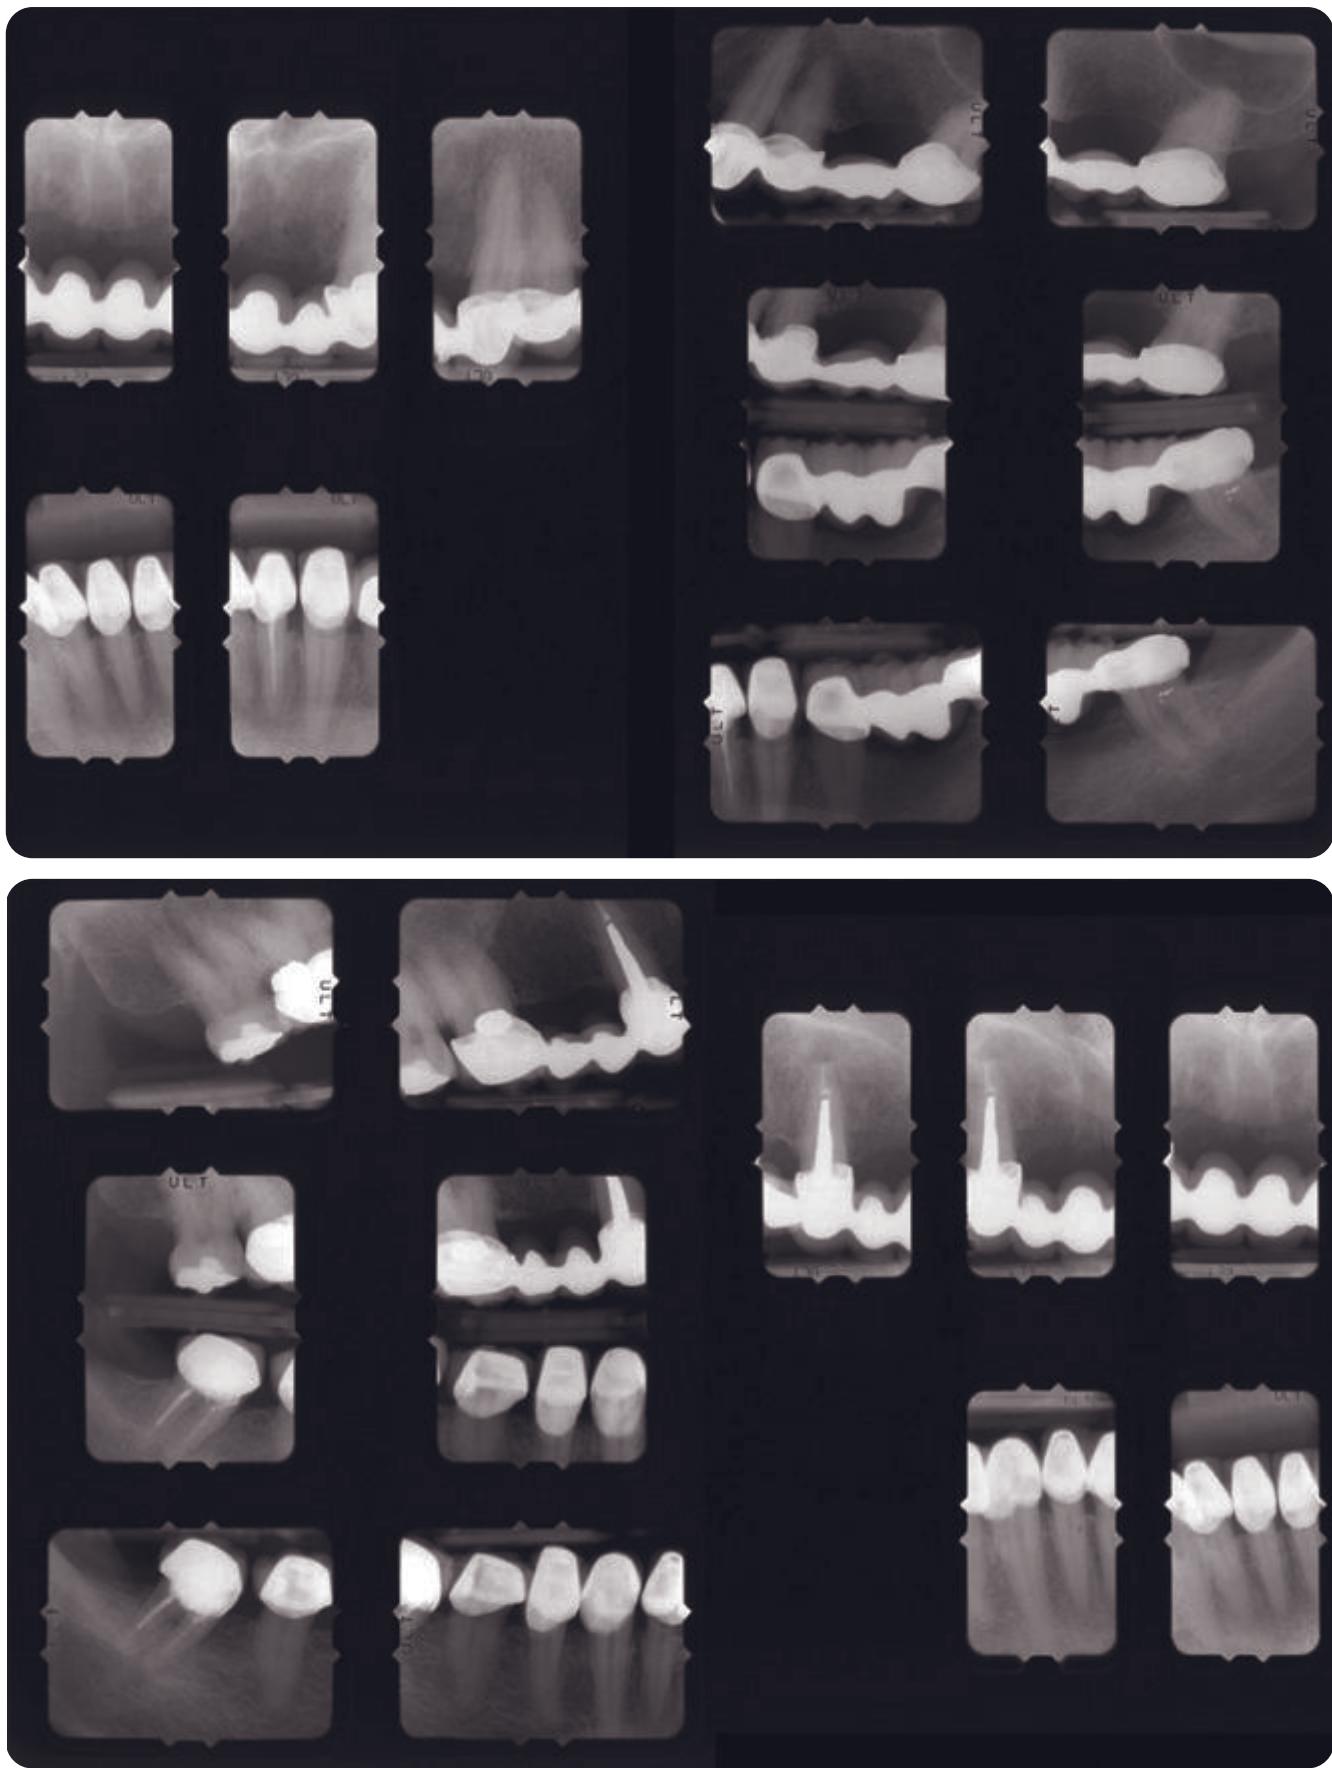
Pretreatment panoramic radiograph. Fixed partial denture abutment number 6 has a poor prognosis due to a large post and core and a suspicious periapical lesion.
